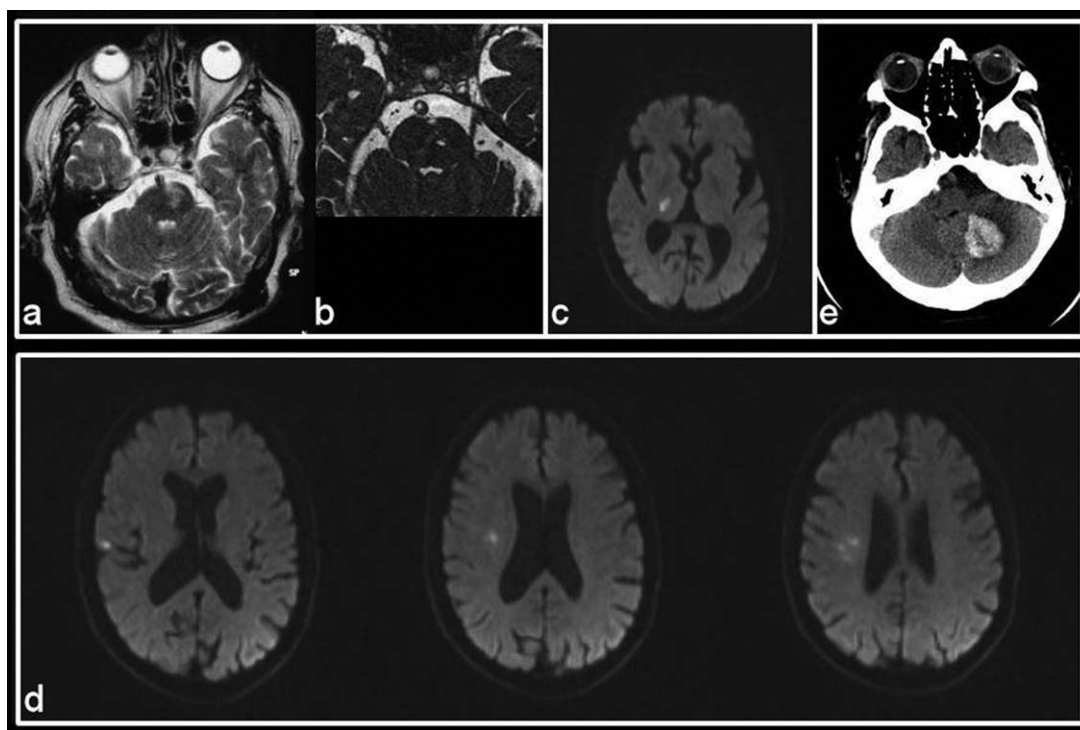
Patient 1: T2-MRI acute stage (a) and 10 months later (b); Patient 2 (c): diffusion-MRI; Patient 3 (d): diffusion-MRI (all the positive diffusion images are shown); Patient 4 (e): CT-scan.
